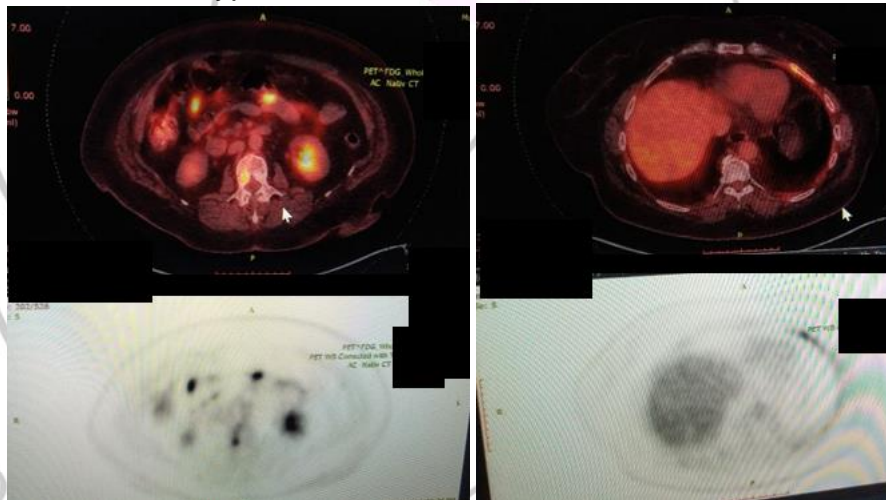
Pet CT scan shows hypermetabolic lesions in bones.
